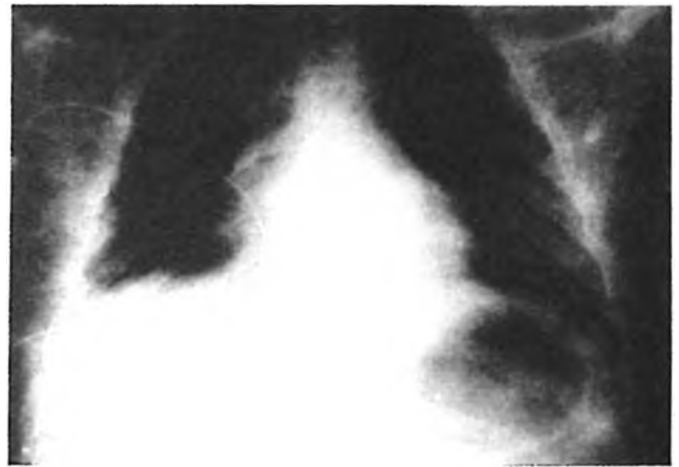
Antero-posterior chest X-ray showed mediastinal broadening.
